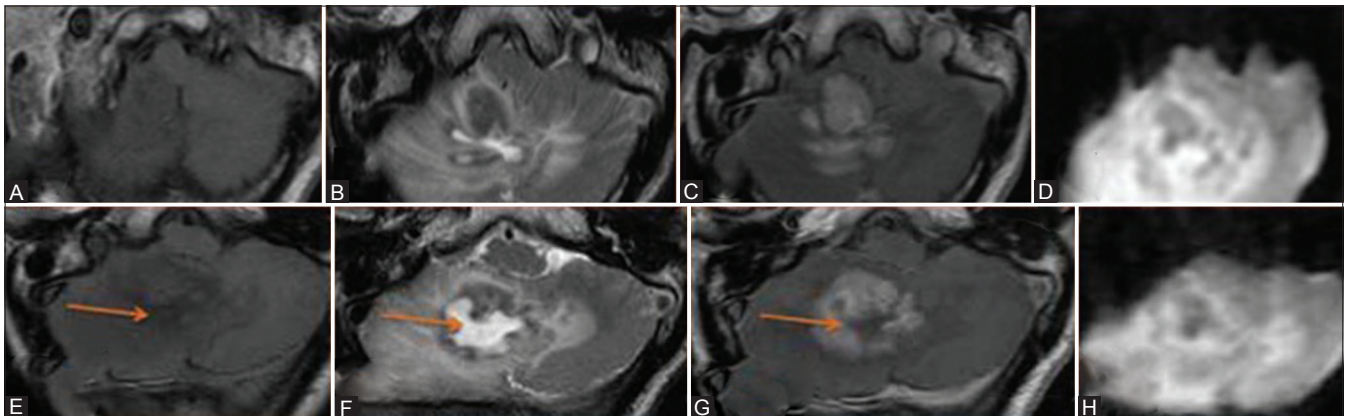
(A-H): History – A 50-year-old immunocompetent man presented with history of headache associated with vomiting since a month. History of gait unsteadiness for 1 month, right > left. MRI revealed a lesion, in the right cerebellum which is isointense on T1W (A), hypo intense on T2 W (B) images with homogenous enhancement of the lesion and adjacent cerebellar folia on post-contrast study (C). There is another lesion (arrow) in the right inferior cerebellar region with central hypo intensity on T1 W (E), hyperintensity on T2 W (F) images and showed a thick, irregular rim-enhancement and non-enhancing central necrosis (G) with restricted diffusion in the periphery on diffusion weighted images (D and H) [and apparent diffusion coefficient not shown in the figure].
